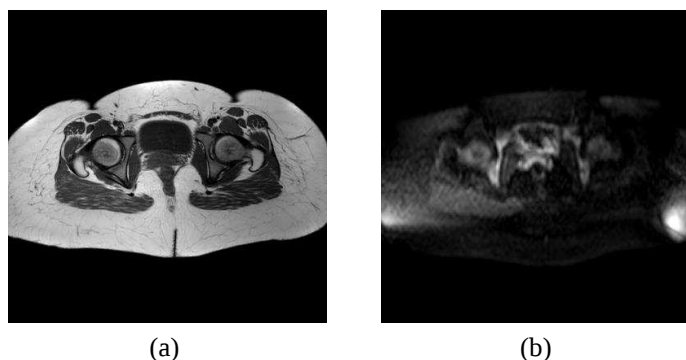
Transversal slices with 2D imaging of the human hip. (a) T1W image. (b) DWI image.
